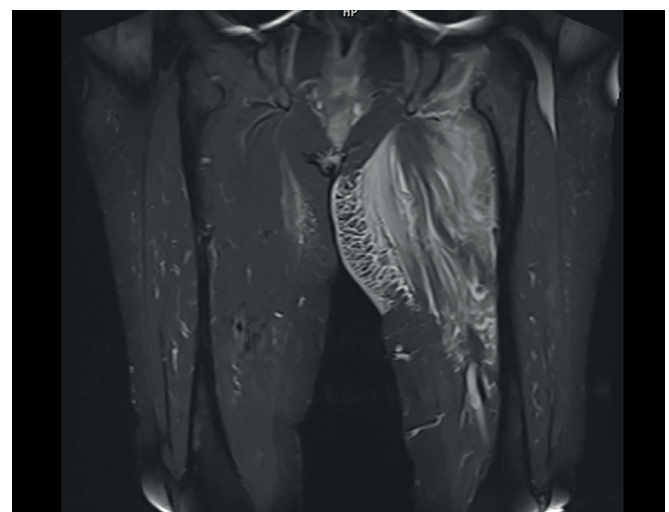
Coronal T2-weighted MRI of the pelvis and thighs showing a hyperintense, organized hematoma localized in the left medial thigh region
